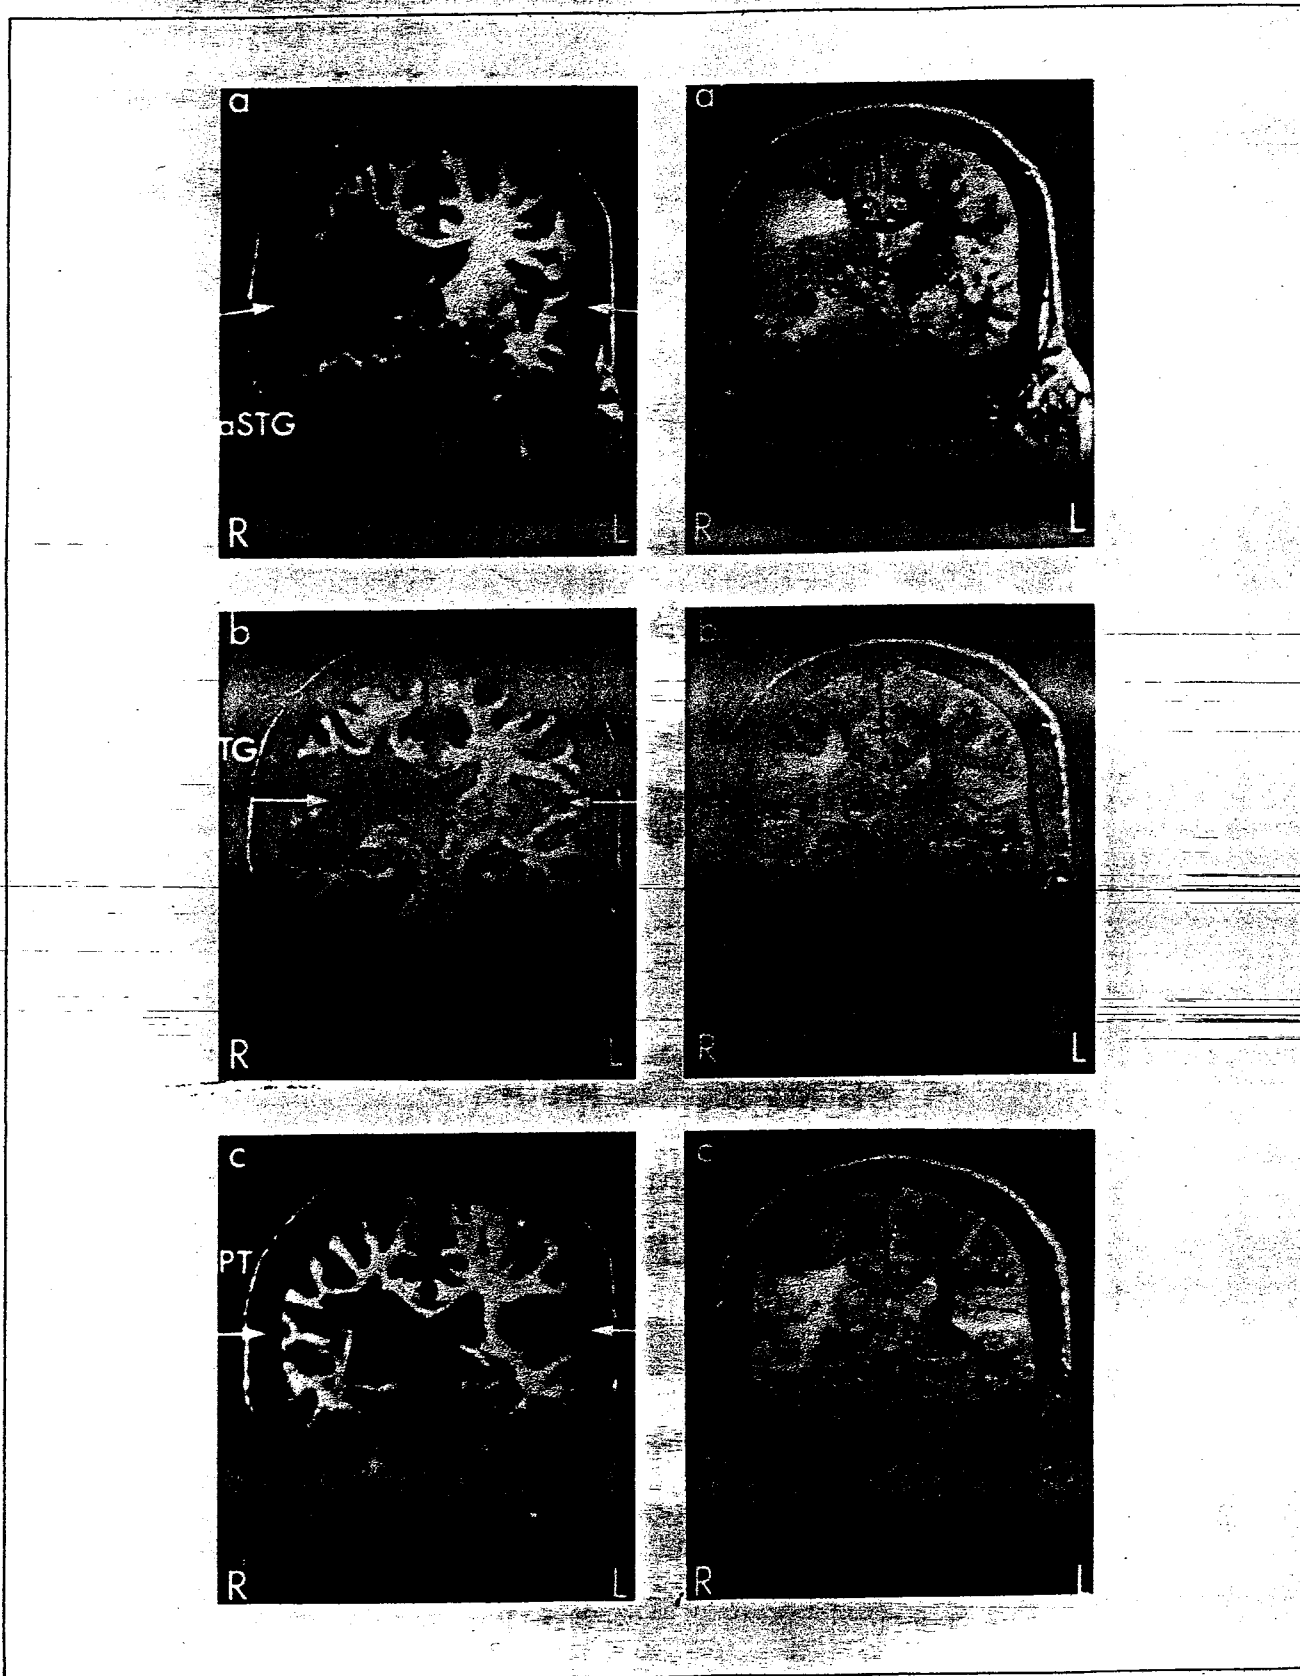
Coronal MR images of the perisylvian region representative of the 20 sections through the area depicted in the brainprints. MRs a and a' are T1- and T2-weighted images, respectively, of the anterior superior temporal gyrus (aSTG). MRs b and b' are sections through the transverse gyri of Heschl (TG); the T2-weighted image clearly demonstrates left- as well as right-sided hyperintense signal abnormalities. Sections c and c' show the planum temporale (PT), that portion of the superior temporal gyrus lying posterior to the transverse gyrus of Heschl. Note the extensive destruction of the deep white matter and basal ganglia in the right hemisphere.
